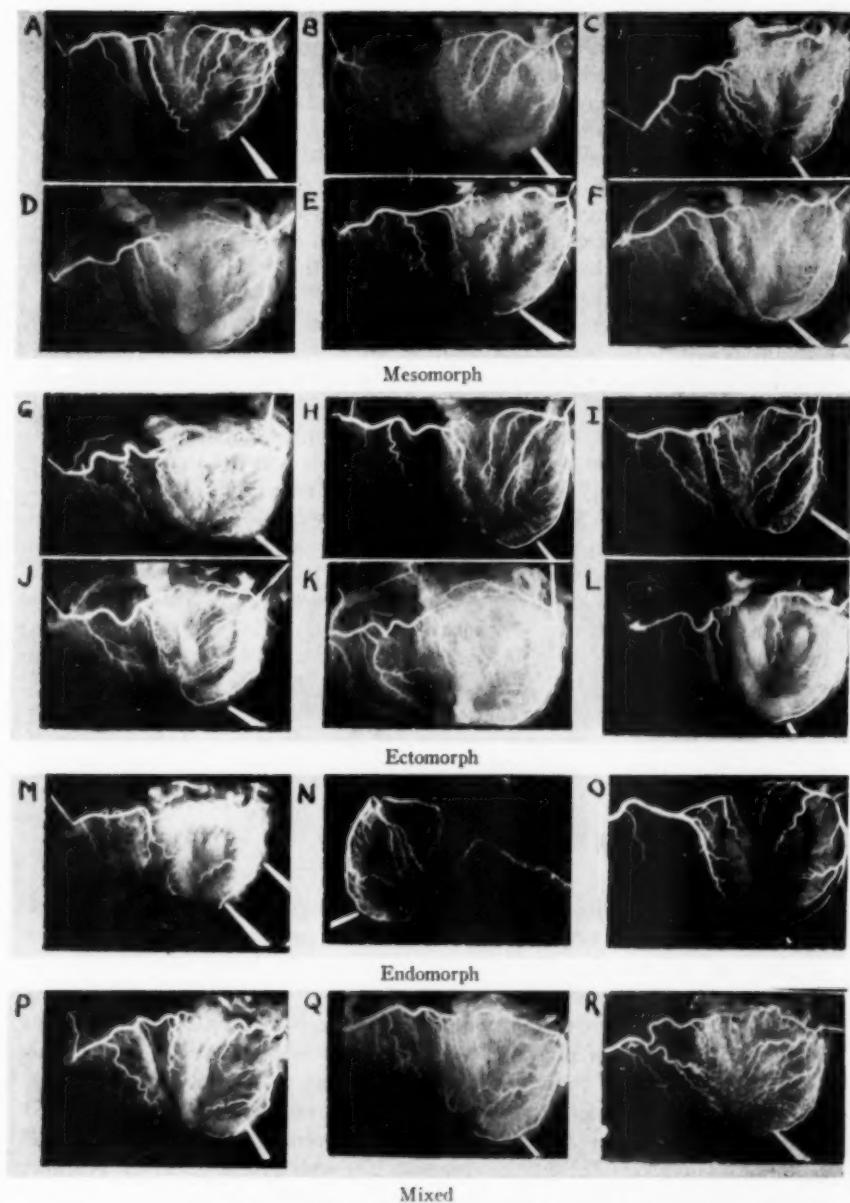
Photographs of representative roentgenograms of injected coronary arteries in the various somatotypes.
